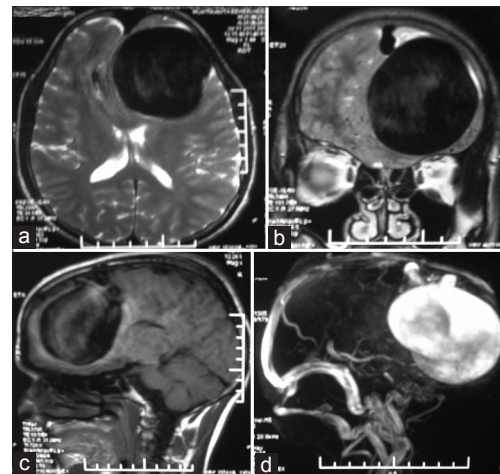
(a) T2 axial, (b) T2 coronal, (c) T1 sagittal and, (d) MR angiogram sequence of cerebral magnetic resonance imaging reveals a left frontal well defined flow void of size 60×66 mm communicating with the superior sagittal sinus through dilated cortical vein with feeder supply from left anterior cerebral artery
